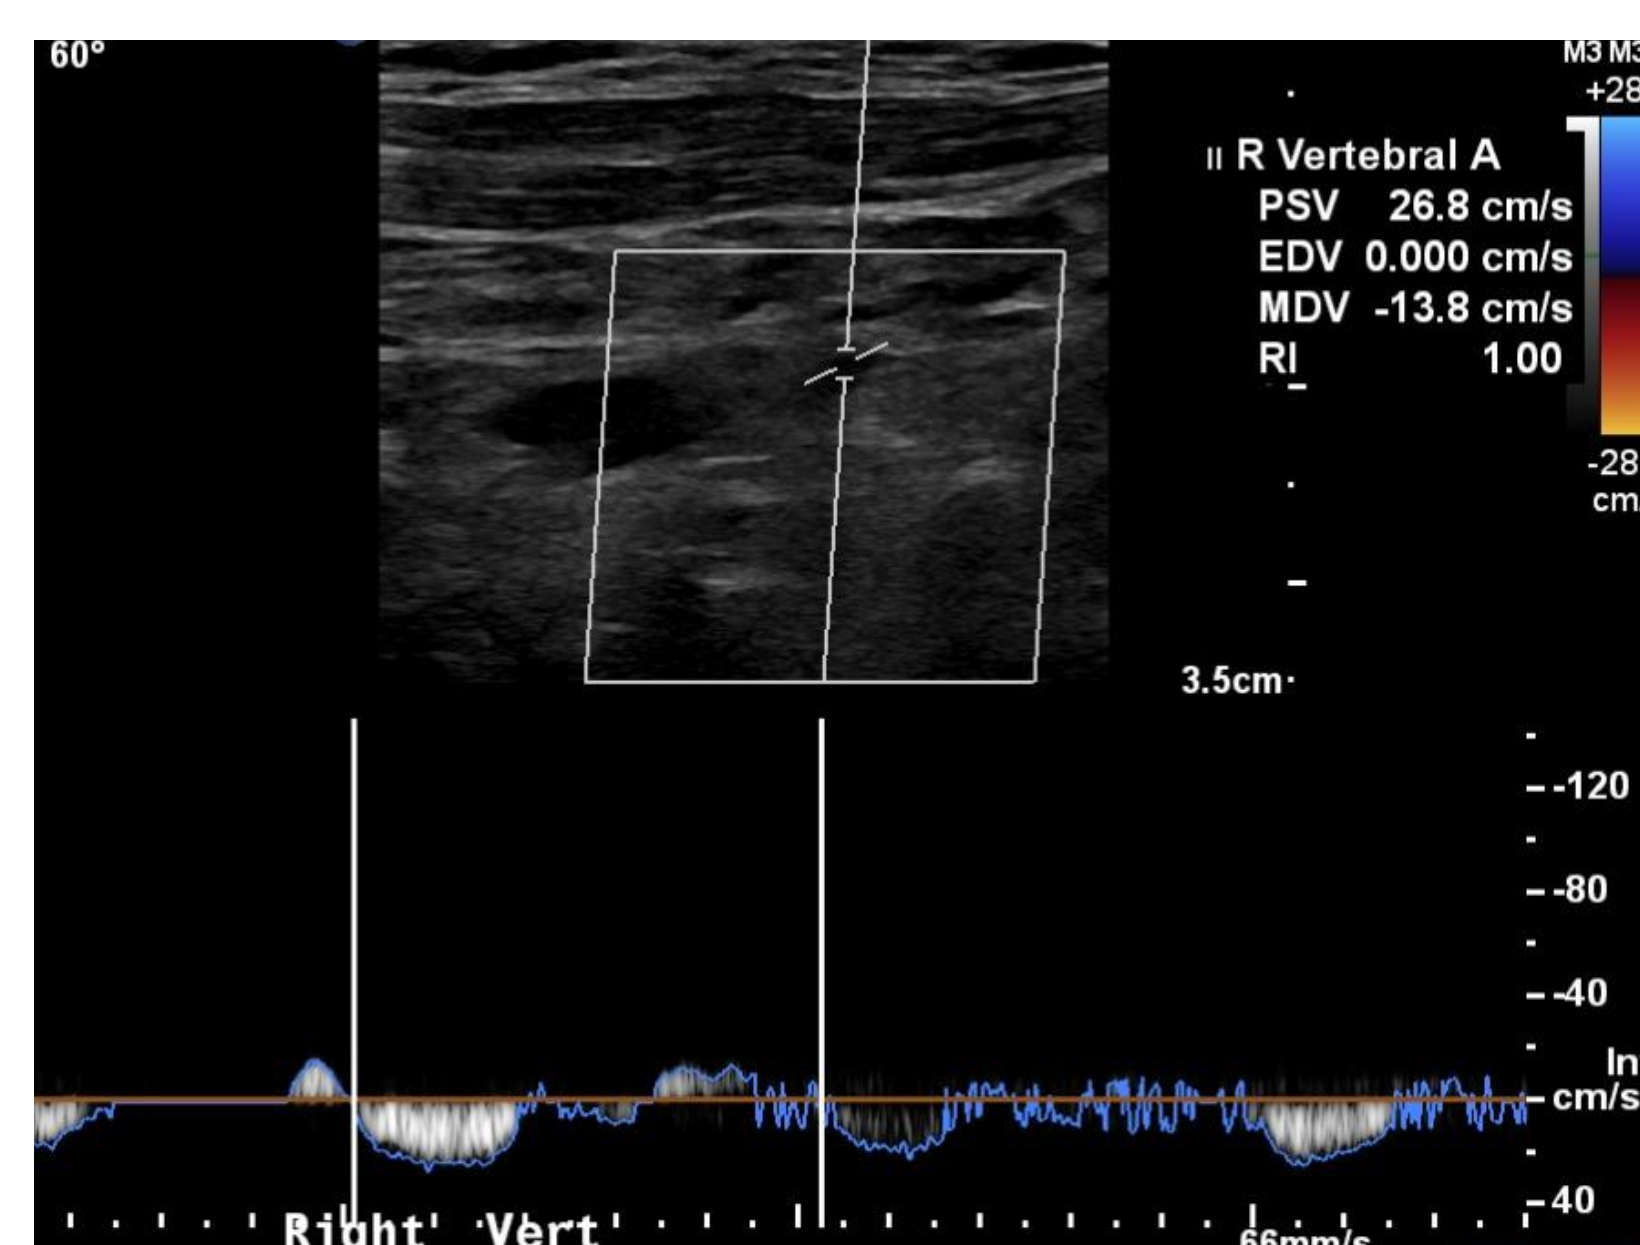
Reversed flow in Right Vertebral Artery on doppler US
